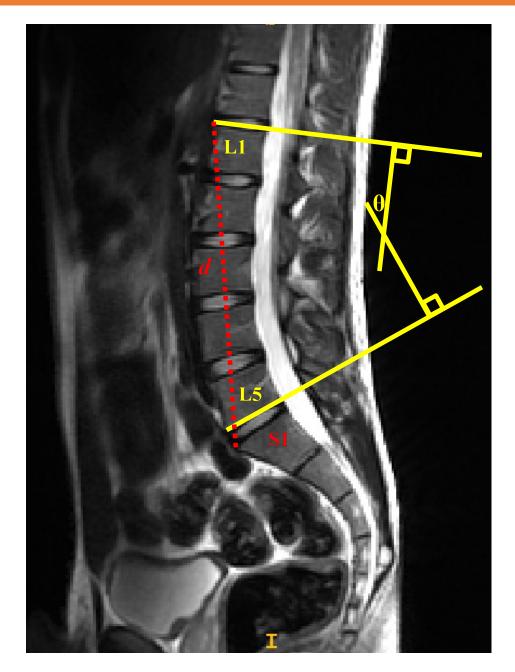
LLA measured using Cobb's method. T2-weighted mid-sagittal MRI image with lines drawn along the superior endplate of L1 and inferior endplate of L5, extending past the vertebral body. Orthogonal lines were added, on the side of convergence of the two lines, and the angle of the intersection (ϑ) was measured. The straight-line distance (d) was measured between the anterior superior border of the L1 vertebra and the anterior superior border of the S1 vertebra.
